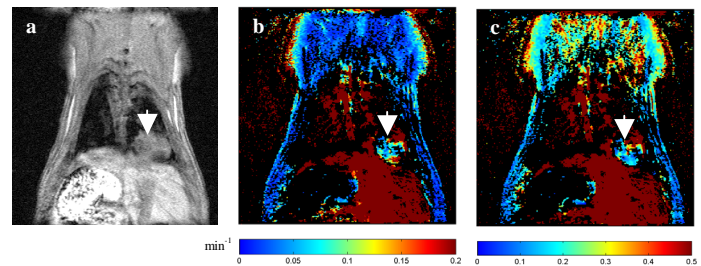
a) MR image acquired 7 minutes post contrast administration, showing a tumor in the right lower lobe. b,c) Parametric maps of k_{in} and k_{ep} respectively. The tumor is marked by an arrow.
